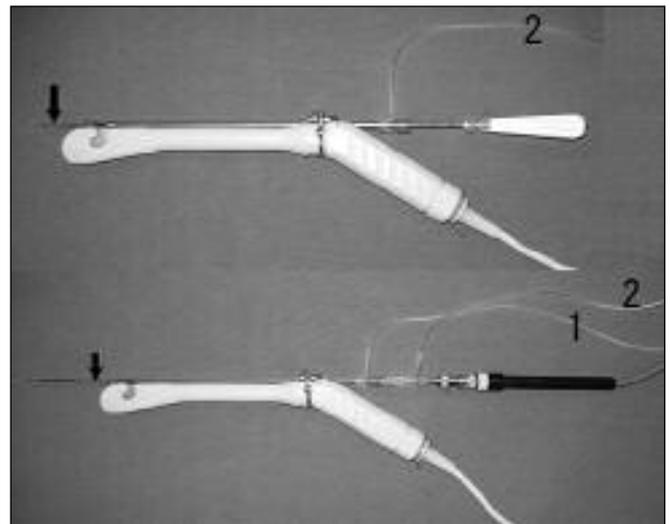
System for ultrasonically guided transcervical microwave myolysis. Upper panel: The sharp end of the guiding needle is covered with a Teflon tube (arrow). Lower: A needle-type applicator is used; 1) tube supplying saline to the irradiation site, 2) cooling of the applicator using saline perfusion.
